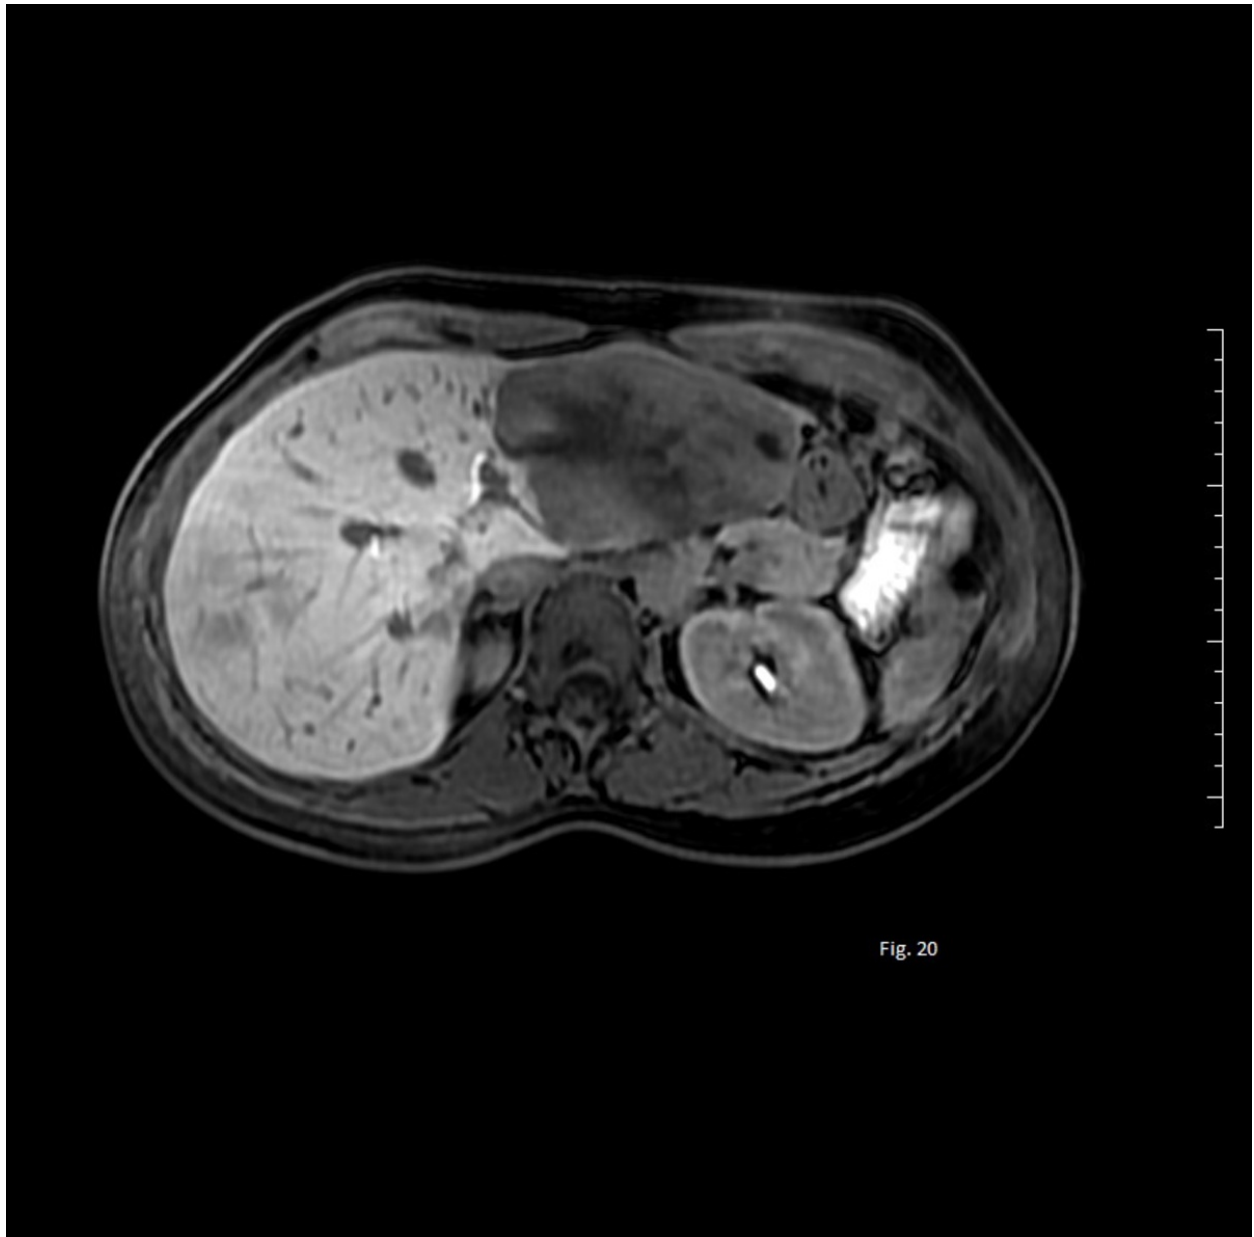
MRI performed three years after diagnosis and OC withdrawal: axial T1 LAVA after gadoxetic acid administration during hepatospecific phase
